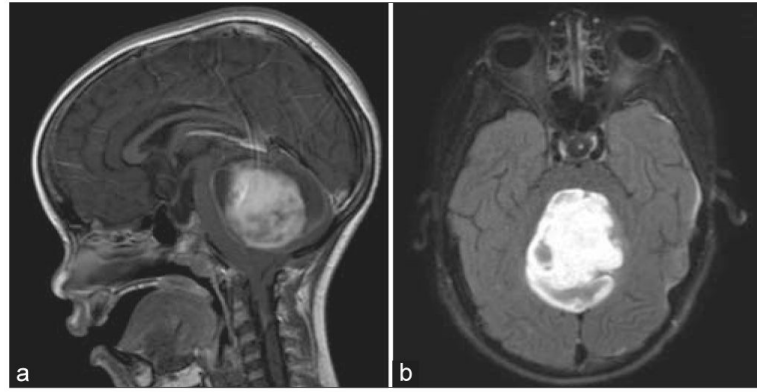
Radiographic characteristics of pilocytic astrocytoma. (a) Sagittal and (b) axial views of a T1-weighted magnetic resonance imaging after contrast administration demonstrating an enhancing mass within the cerebellum
